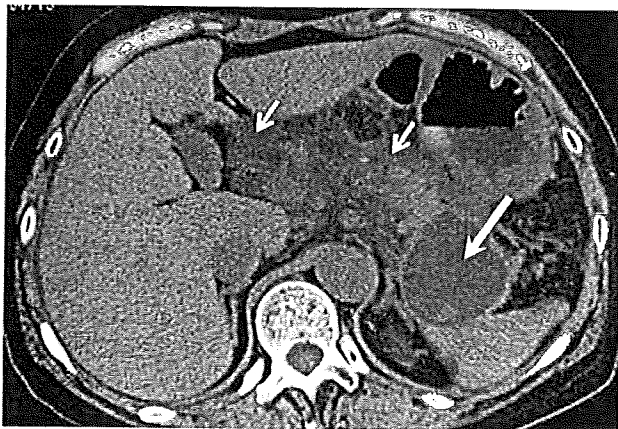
Plain CT shows fluid in the parapancreatic cavities (small arrows) and pseudocyst formation in the pancreatic tail (large arrow)
